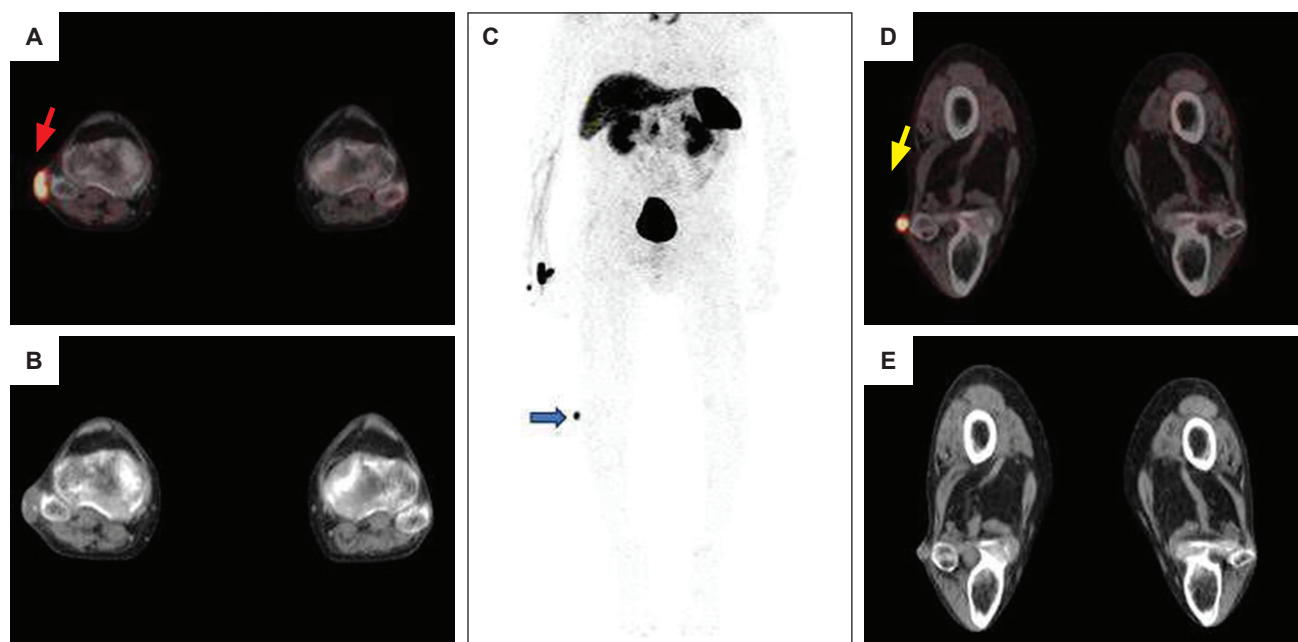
⁶⁸Ga-DOTANOC PET/CT localization of the tumor causing tumor-induced osteomalacia (TIO). (A) Fused PET/CT images show a focal area of tracer uptake (red arrow) in the soft tissue over the lateral aspect of the proximal right fibula, compared with the normal contralateral leg. (B) Corresponding CT images of the same region, without PET overlay. (C) Whole-body PET image showing normal background tracer uptake (pituitary, liver, spleen, kidneys) and a single abnormal focus in the right leg (blue arrow), corresponding to the tumor. (D) Fused PET/CT images at a second level, again showing the tracer-avid lesion (yellow arrow), with the normal leg for comparison. (E) CT images (bone window) showing a normal, intact fibula, confirming the tumor lies in the soft tissue and does not involve the bone.
